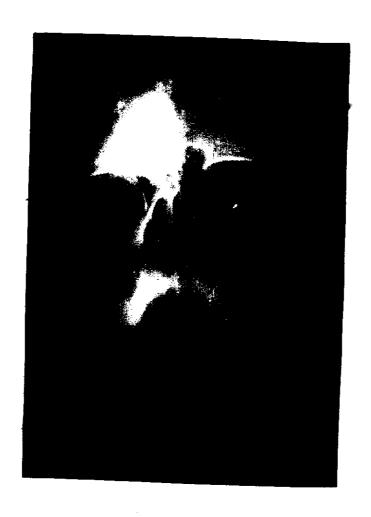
X-ray of maxillary sinuses, occipitomental view with open mouth, showing small sized cavity of both maxillary sinuses, with partial opacity of right side.
